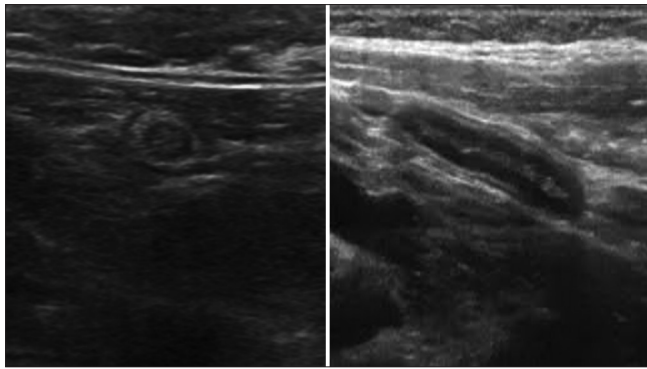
Appearance of normal appendix on transabdominal ultrasonography scan, as seen in axial view (left) and longitudinal view (right). Note the stratified appearance of the wall as seen in a normal appendix on ultrasound
